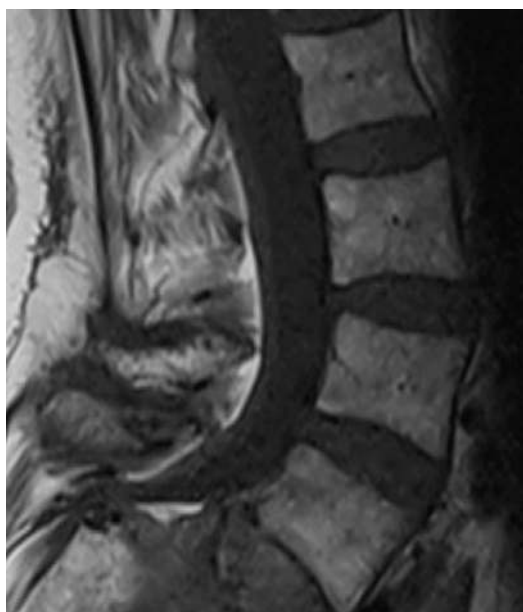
Enlargement of interapophyseal fluid space on T2-weighted image
